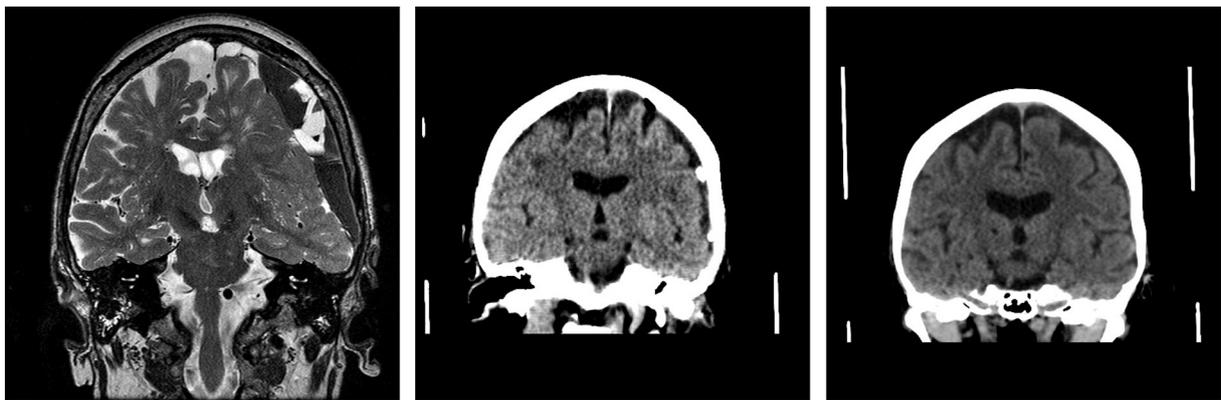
Imaging from case 5. A: Pre-operative coronal T2 weighted MRI image demonstrating mixed signal intensity left SDH with mass effect on the left hemisphere and midline shift. B: Post-operative coronal reformatted CT demonstrating SDD with decreased size of left side SDH with decreased mass effect and shift. There is mild pneumocephalus. C: 1-month follow-up CT demonstrating almost complete resolution of SDH.
